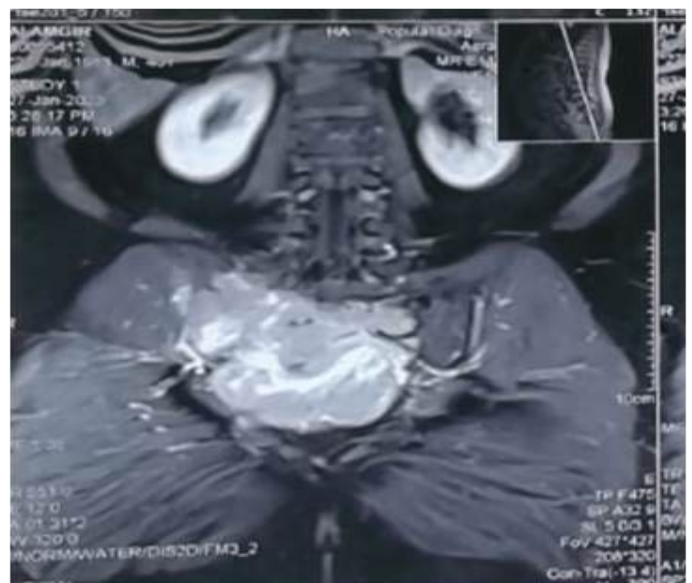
MRI showing large lobulated soft tissue lesion with bony destruction of all sacral vertebrae
